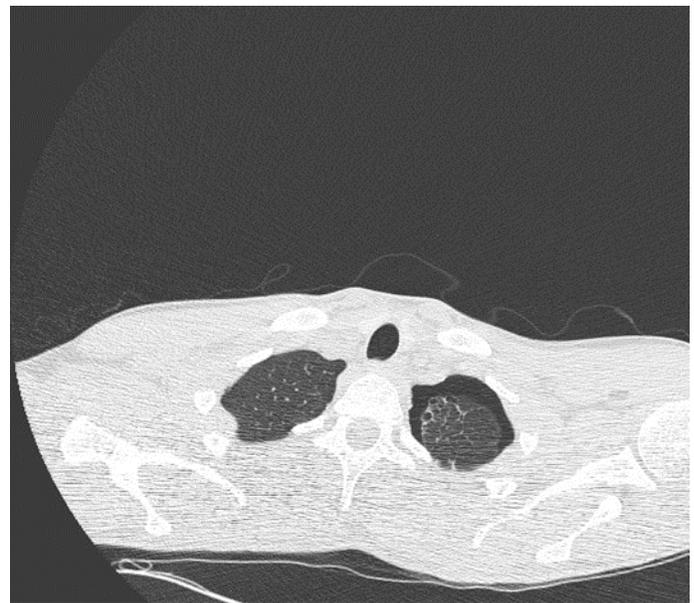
CT scan of the chest on the same patient with PSP showing sub pleural emphysema like changes at the left lung apex
